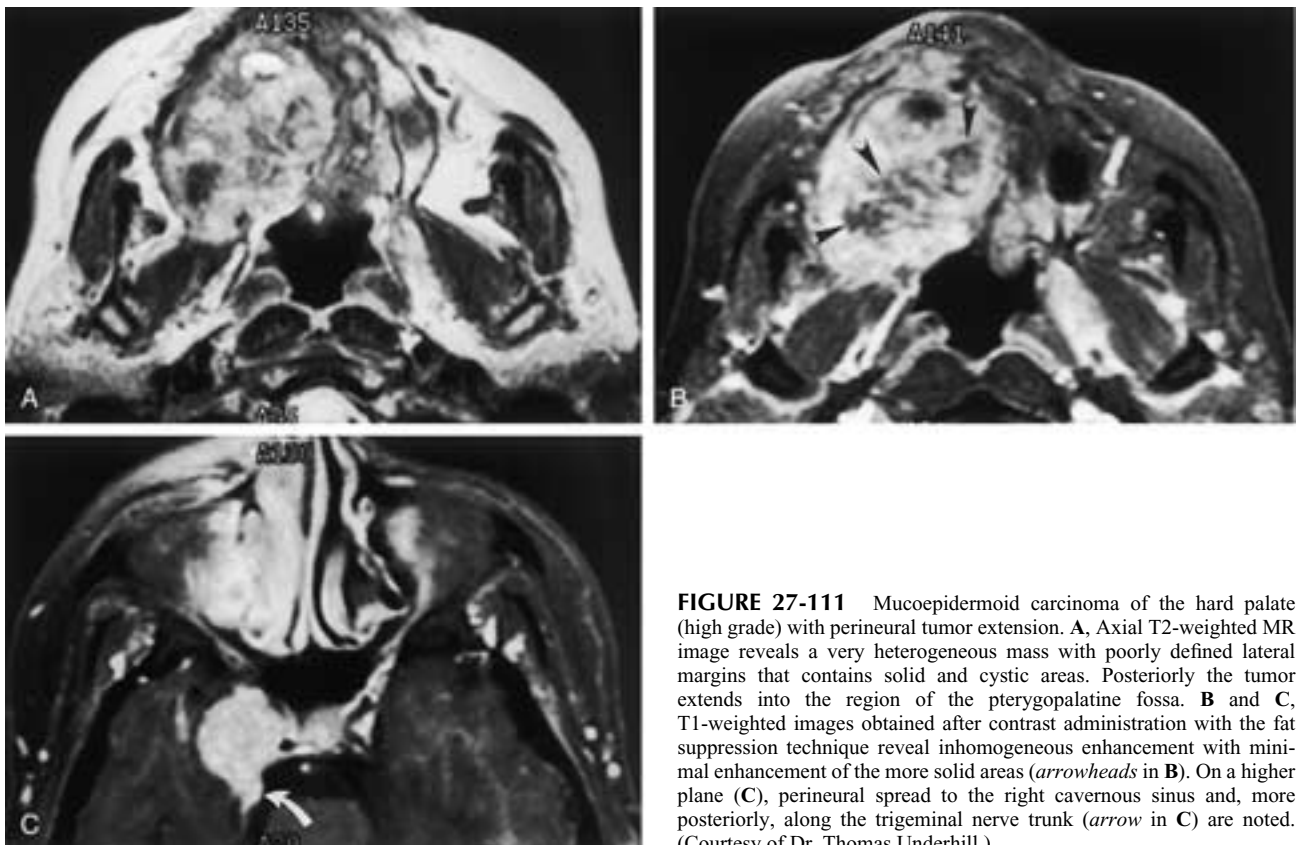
Mucoepidermoid carcinoma of the hard palate (high grade) with perineural tumor extension. A, Axial T2-weighted MR image reveals a very heterogeneous mass with poorly defined lateral margins that contains solid and cystic areas. Posteriorly the tumor extends into the region of the pterygopalatine fossa. B and C, T1-weighted images obtained after contrast administration with the fat suppression technique reveal inhomogeneous enhancement with minimal enhancement of the more solid areas (arrowheads in B). On a higher plane (C), perineural spread to the right cavernous sinus and, more posteriorly, along the trigeminal nerve trunk (arrow in C) are noted. (Courtesy of Dr. Thomas Underhill.)
